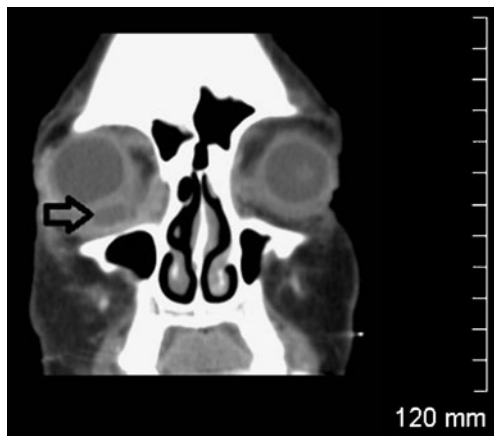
Orbital CT scan in coronal imaging plane. Extra-orbital inflammation and edema is seen just medial to the right orbit suggestive of an organizing phlegmon (arrow)
